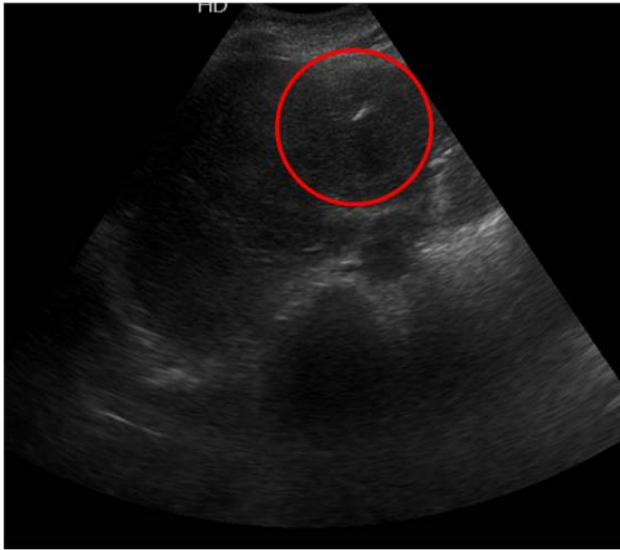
Real time ultrasound guided FNAC from liver nodule showing needle tip in the target lesion.
